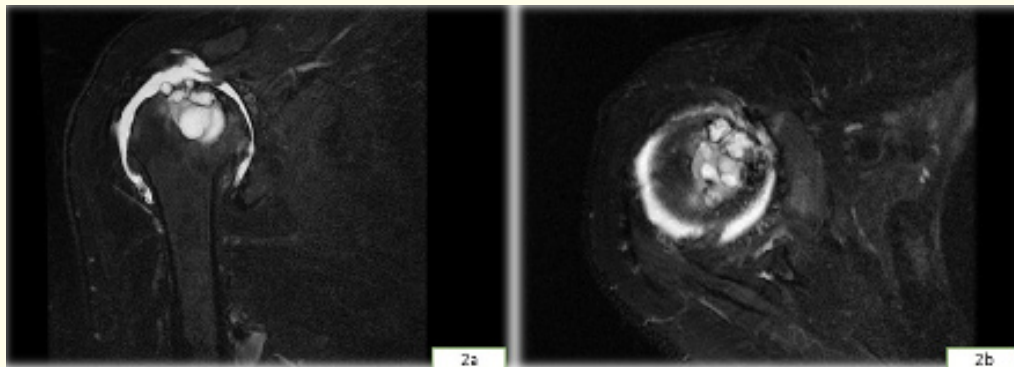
Magnetic resonance images of coronal and axial images.
